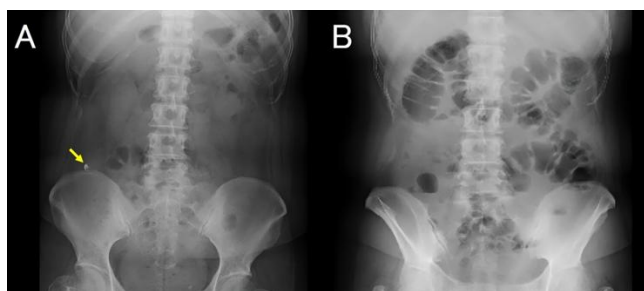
Abdominal X-ray confirming the disappearance of a radiopaque lesion (arrow) indicating the barolith (panel A: pre-procedure and panel B: post-procedure) (reprinted with permission of the patient)
